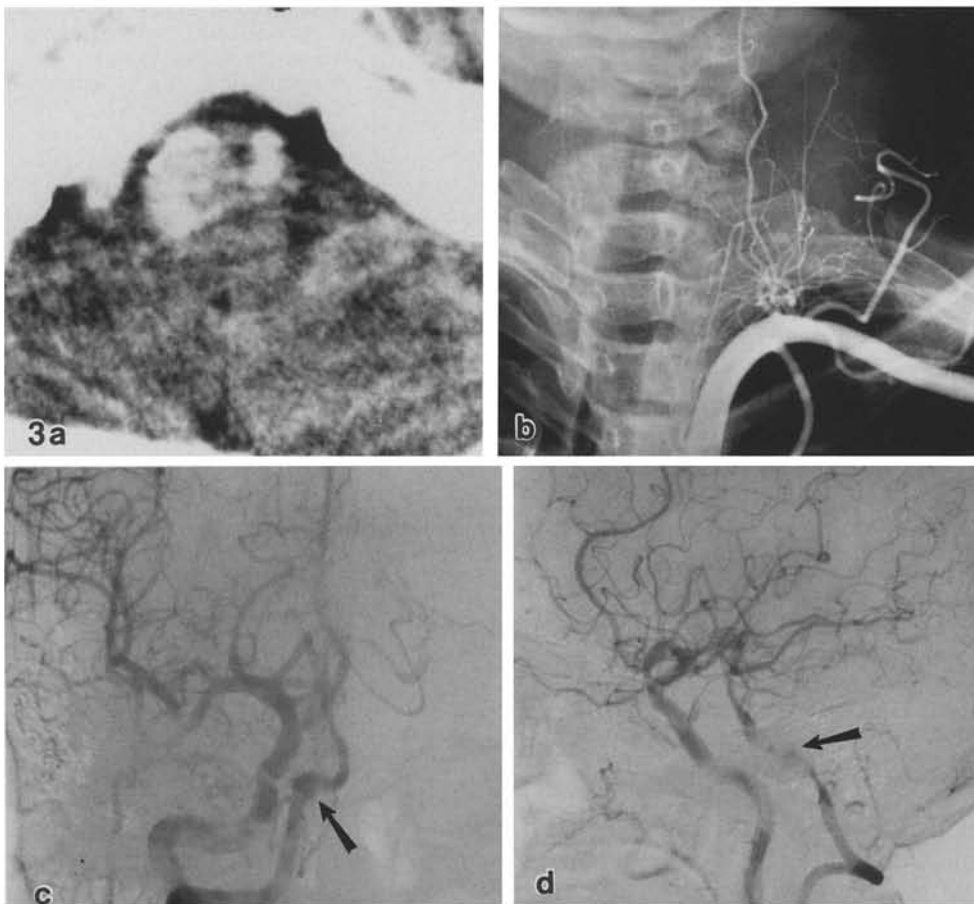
a-d. Case 2. Contrast enhanced CT (a) depicts two hyperdense masses located ventral to the medulla oblongata. The left vertebral artery is not filled on the left vertebral angiography conducted using a trans-brachial artery method (b). Antero-posterior (c) and lateral (d) views of the right vertebral angiogram showing irregular narrowings accompanied by a dilatation of the right vertebral artery (arrows)
